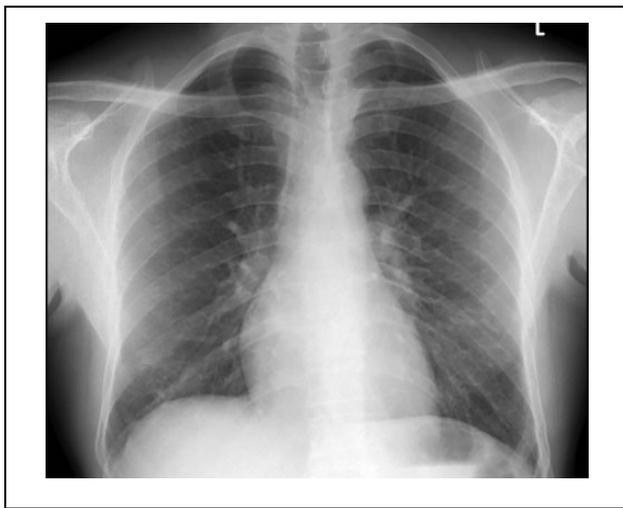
Posttreatment radiograph showing resolution of the left lower lobe mass and smaller nodules.
